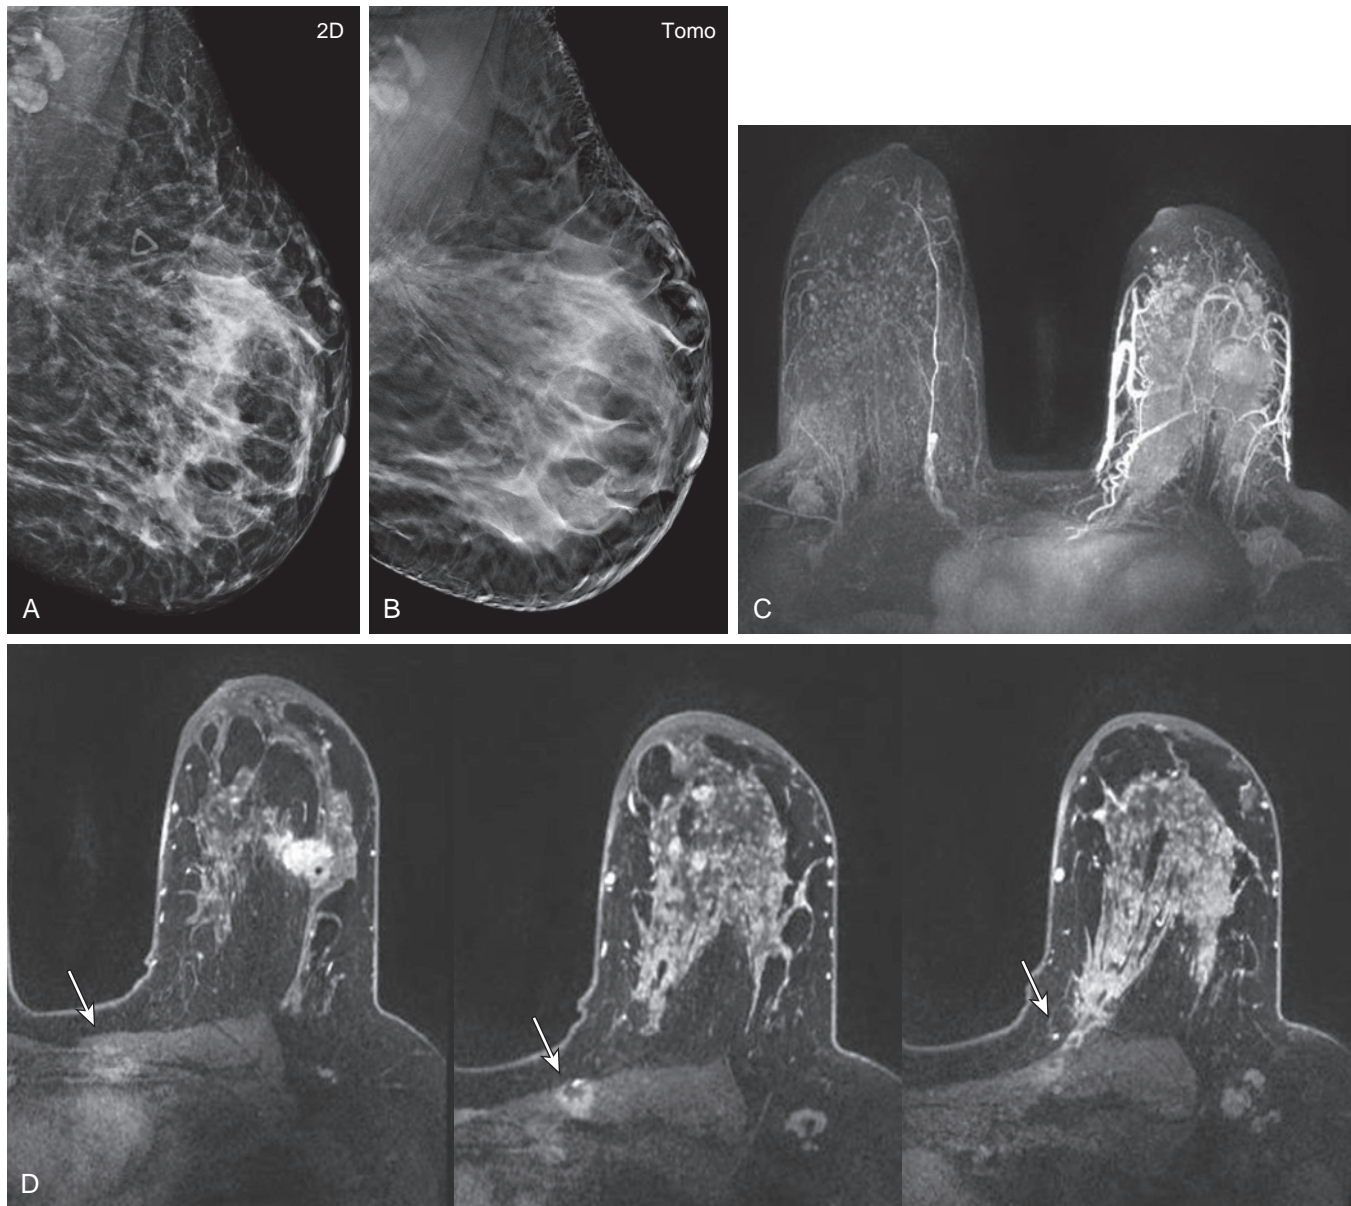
(A) A 43-year-old woman presented with a large, palpable, spiculated mass in the left breast. (B) Tomosynthesis mediolateral oblique view demonstrates the cancer causing distortion of the underlying pectoralis muscle. Biopsy yielded invasive ductal carcinoma, ER+/PR+/Her2-. (C) Maximum intensity projection view of MRI shows the large extent of malignancy involving multiple quadrants of the left breast. (D) Multiple axial post-contrast post contrast images confirm the chest wall involvement with disease seen extending through the pectoralis and intercostal spaces (*arrows*).
